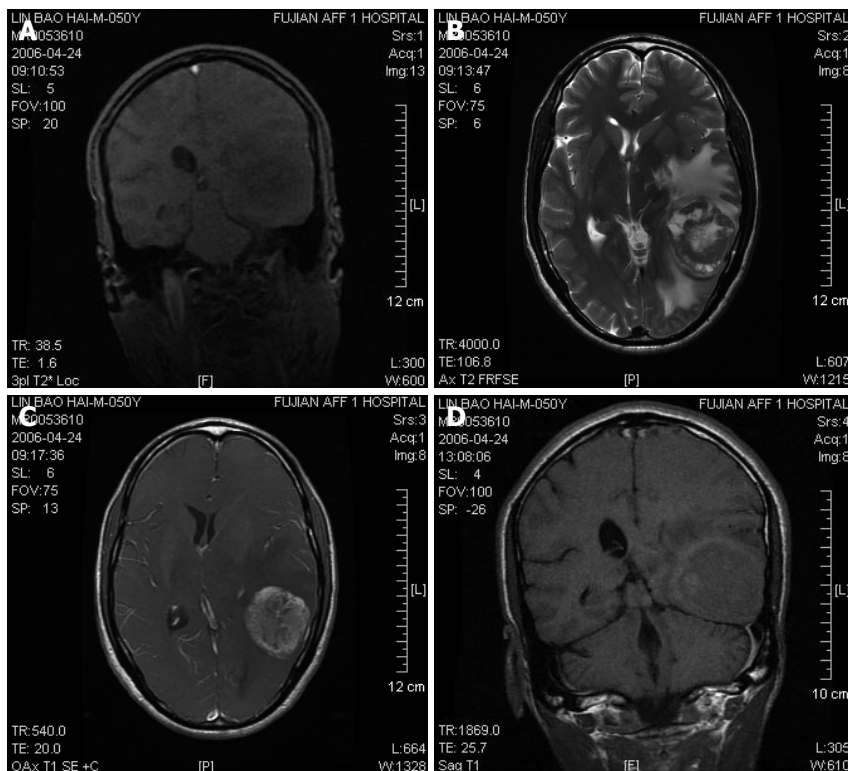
MR imaging revealing a spherical occupying lesion in the left posterior-temple lobe with a high intensity on T₂-weighted images and irregular contrast enhancement with a clear boundary and uneven signal in size of about 6.0 cm × 4.8 cm × 4.0 cm after administration of gadolinium-diethylene triamino pentaacetic acid (Gd-DTPA). A: Coronal gradient-recalled echo; B: Cross-sectional T₂WI; C: Cross-sectional contrast enhancement T₁WI; D: Coronal T₁WI-delayed scan 4 h after contrast media injected via veins.
